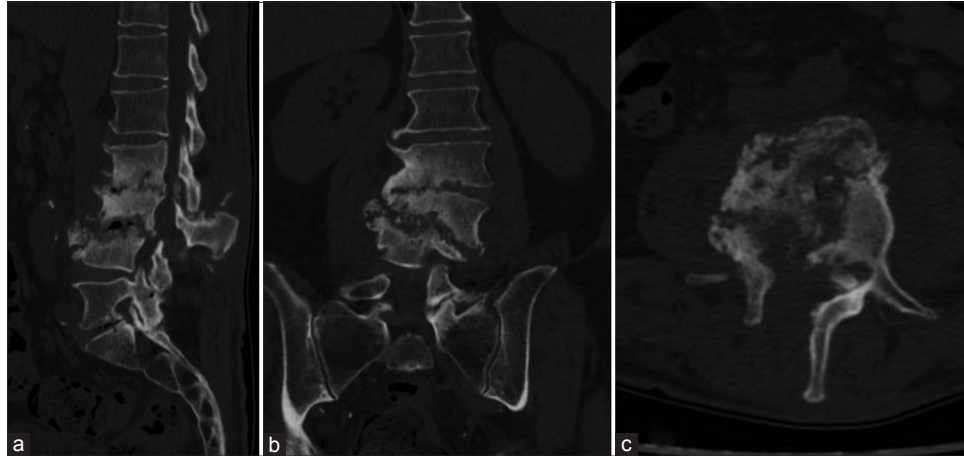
(a) Sagittal, (b) coronal, and (c) axial post-operative computed tomography scans of the patient affected by *Parvimonas micra*-related spondylodiscitis, showing complete structural alteration of L2, L3, and L4 and the presence of laminectomy, as shown in the (c) axial view.
